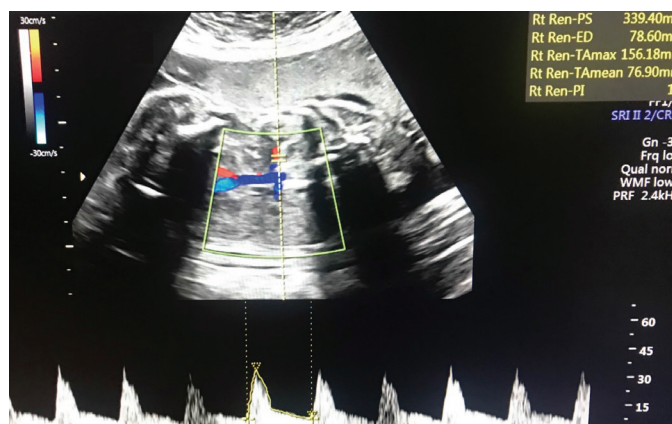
Measurement of fetal renal artery Doppler
